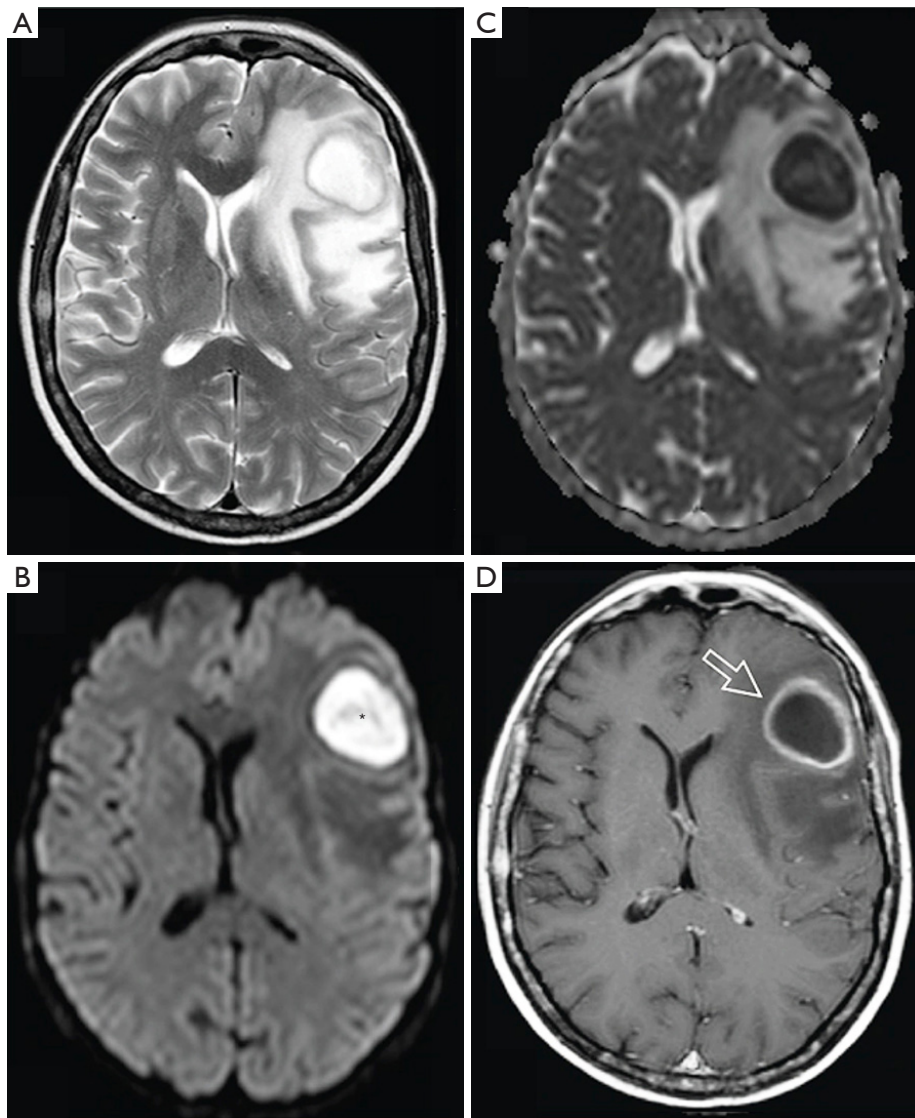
MRI of a 37-year-old woman with pyogenic abscess in the left frontal lobe (A: T2-weighted image; B: diffusion-weighted image; C: ADC map; D: contrast-enhanced T1-weighted image). The central component of the lesion shows high signal on T2-weighted image, high signal on diffusion-weighted image (asterisk in B) and low value on ADC map (C, lower than the brain tissues). Arrow in (D) denotes a ring enhancement after contrast agent administration. It appears unreasonable that the abscess content has a so low ADC measure. Adapted from Feraco *et al.* (1). MRI, magnetic resonance imaging; ADC, apparent diffusion coefficient.
